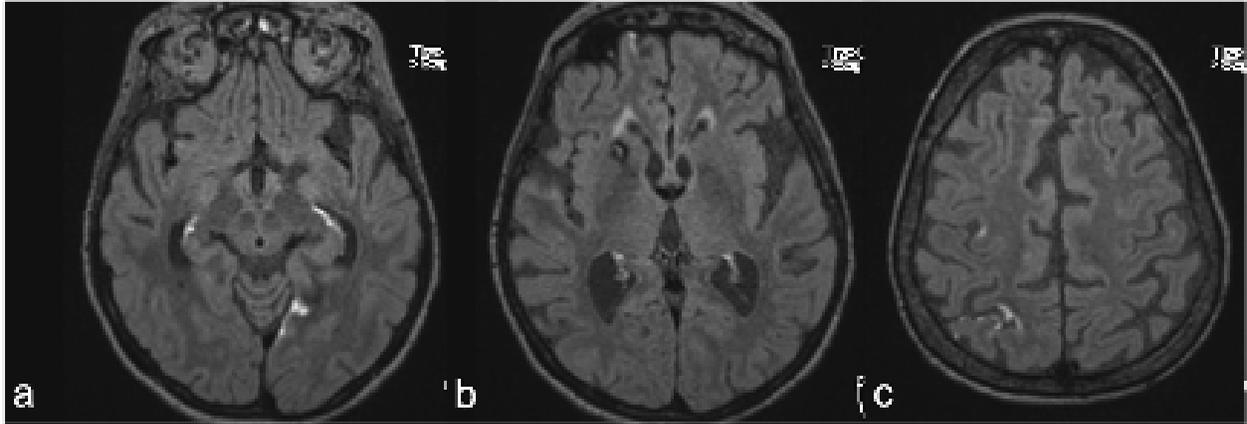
69 year-old intubated female patient. Post-contrast 3D FLAIR images (a-c) show mild linear pial-subarachnoid enhancement in the left occipital lobe (a), right parietal (b) and posterior frontal lobes (b). There is an incidentally noted cavernoma adjacent to the head of right caudate nucleus (c). These enhancements are only depicted on post-contrast 3D FLAIR images with no discrete evidence of enhancement on the post-contrast T1WI and post-contrast TurboFlash T1WI (images not provided). Increased protein level was depicted in CSF analysis.
